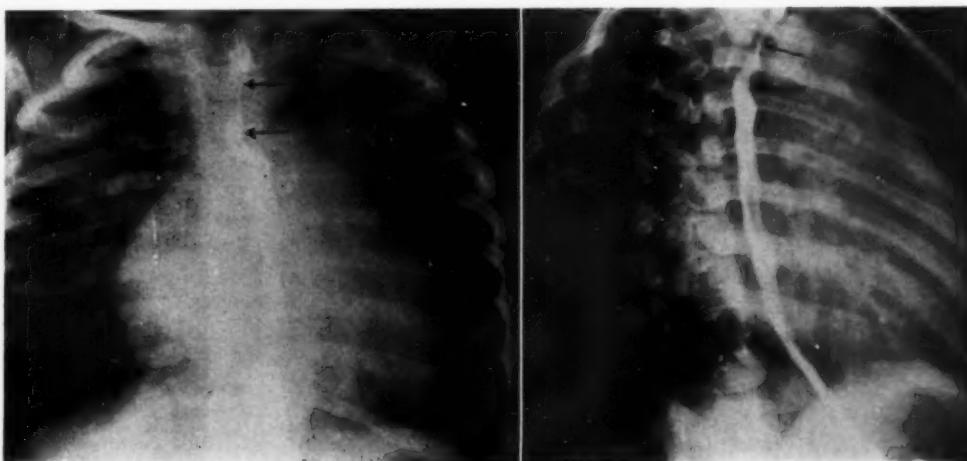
Roentgenograms of chest of child three and a half years old, demonstrating unusual impression on barium-filled esophagus immediately below aortic impression. This impression was produced by a large patent ductus measuring 11 mm. in diameter.
